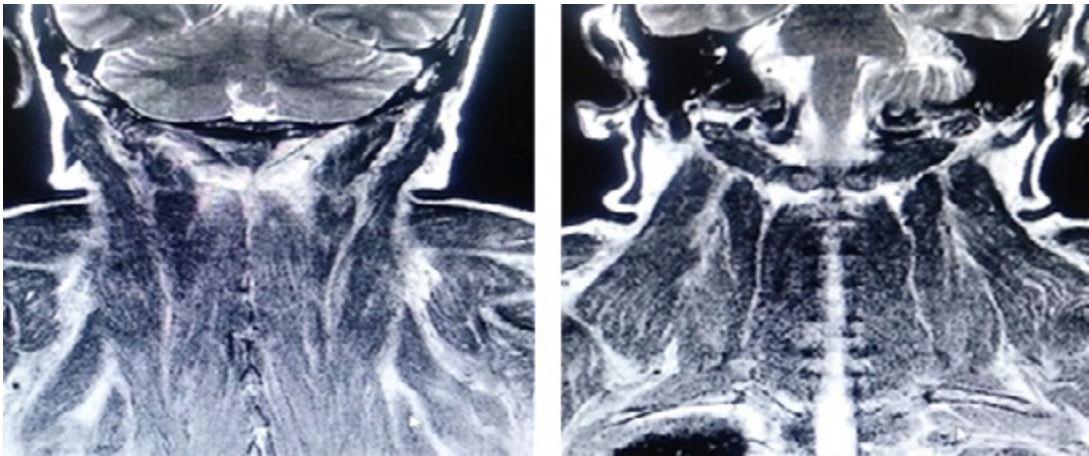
Contrast-enhanced MRI of the head and neck, coronal plane, with paraspinal muscular edema.
